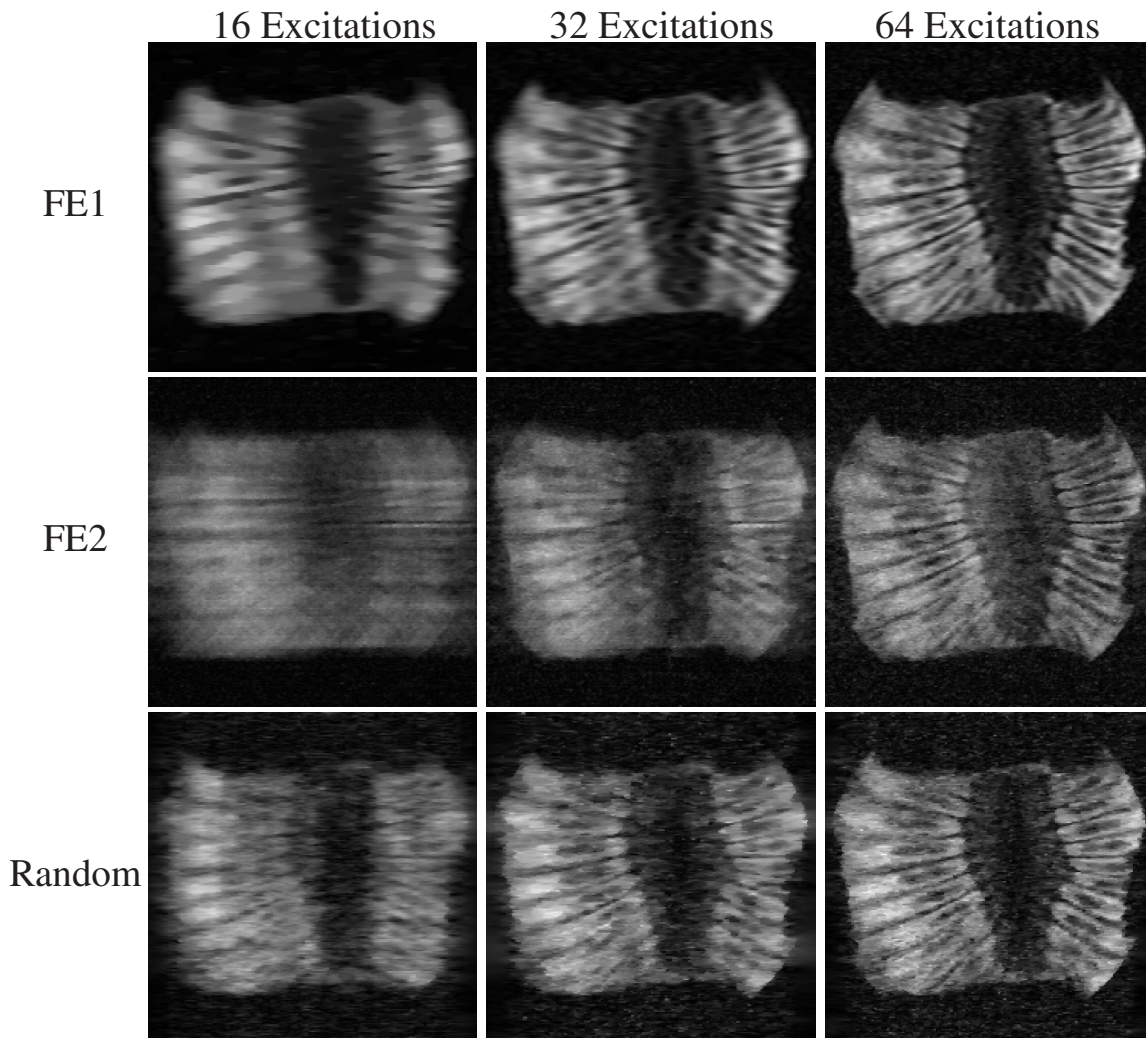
CS-MRI reconstructions of real experimental data from the section of kiwi fruit. Each row represents a different encoding scheme, while each column represents a different amount of measured data. As before, random encoding enables visualization of both low- and high-resolution image features with very limited data.
